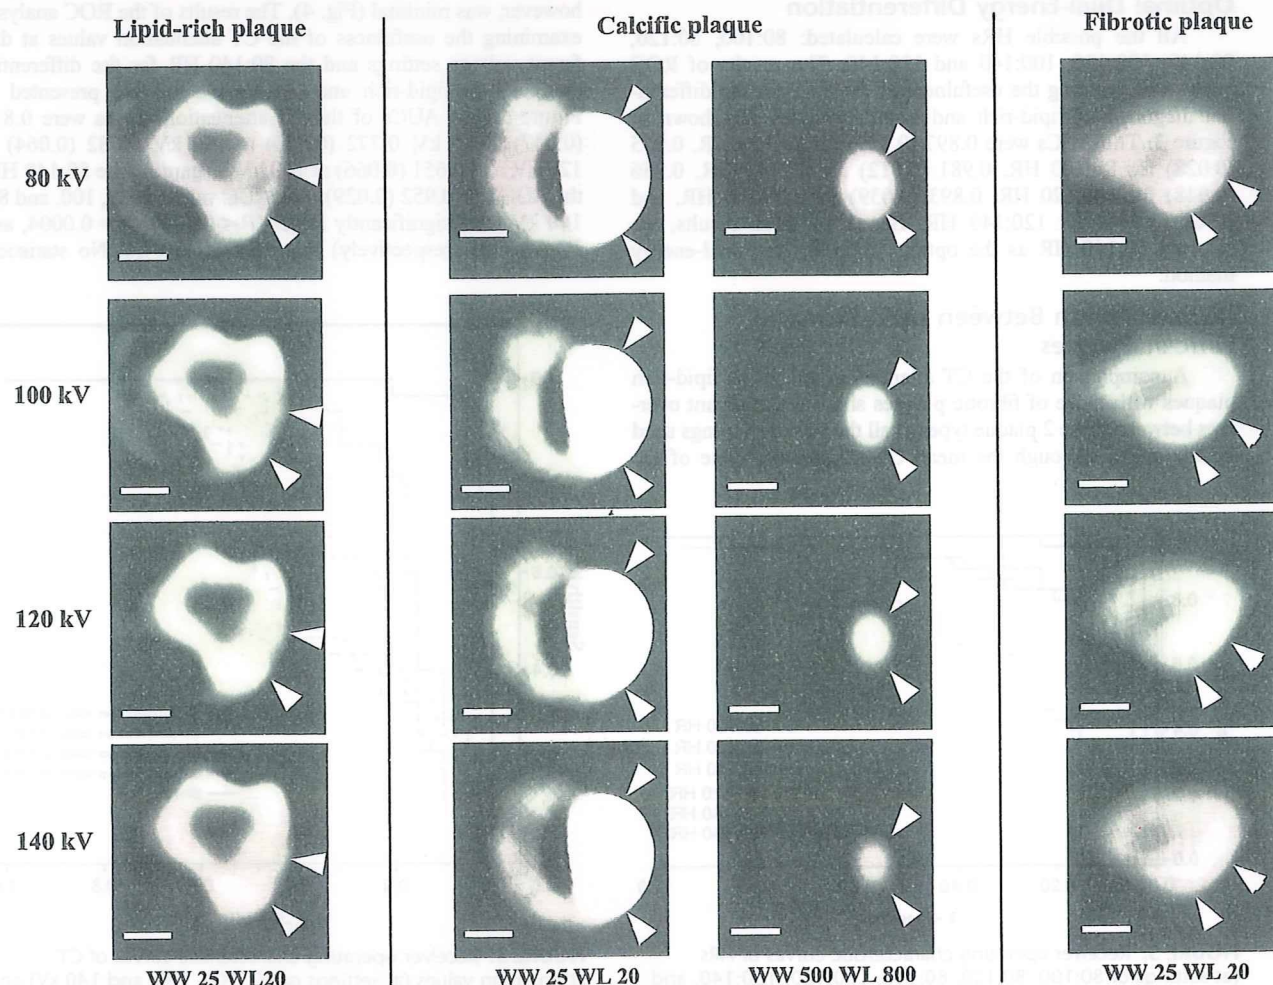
Computed tomographic images of coronary arteries at different energy settings. Computed tomographic images of the coronary arteries shown in Figure 1 are presented, and the areas of the plaques are indicated by the arrowheads. Bars, 1 mm.
